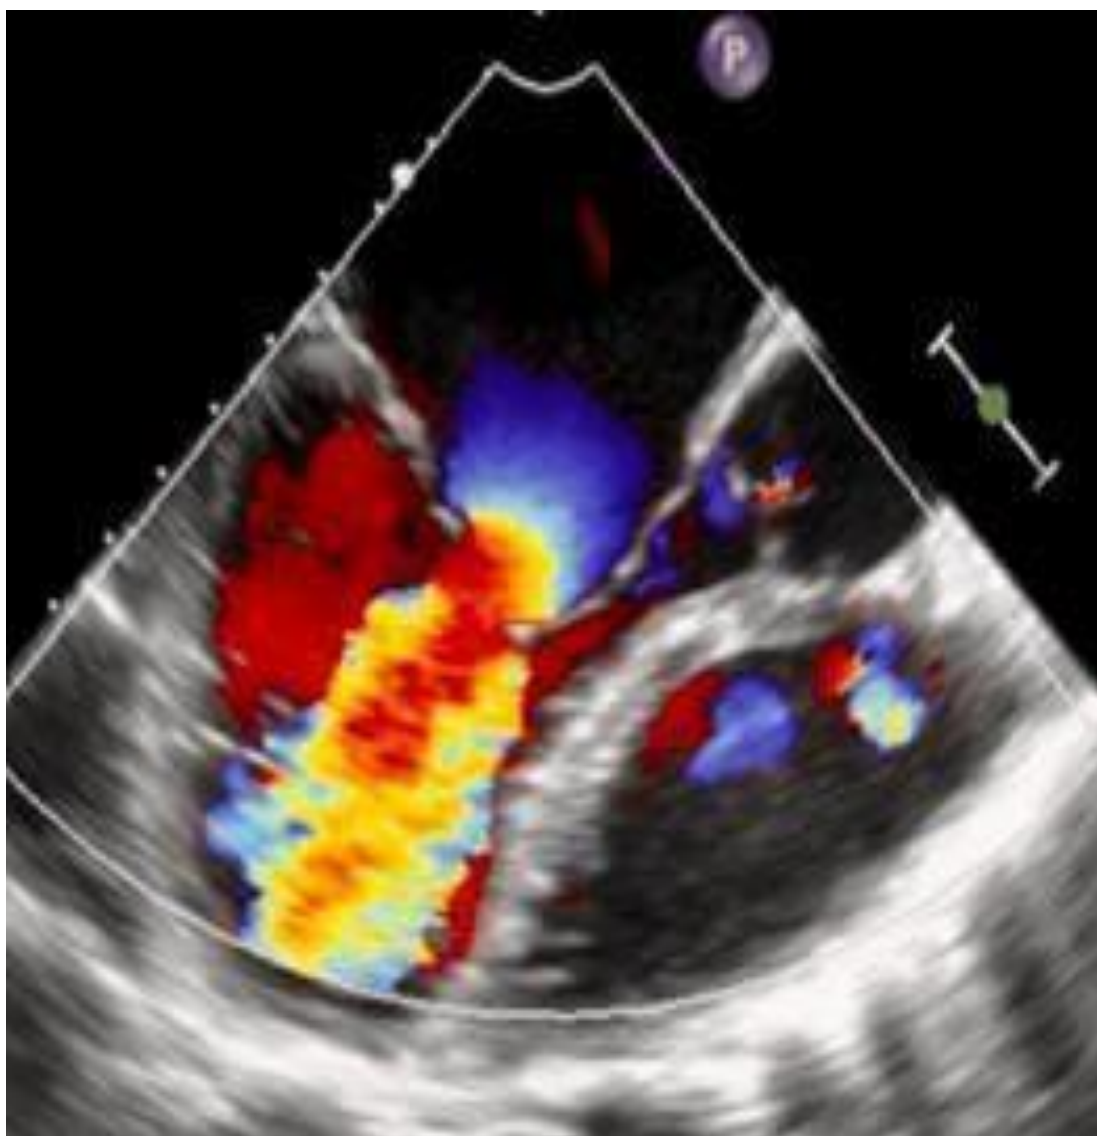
Transesophageal echocardiography (TEE) with color Doppler showing turbulent, high-velocity diastolic flow across a stenotic mitral valve (aliasing at the valve orifice and increased trans-mitral flow acceleration) consistent with significant mitral valve stenosis.
